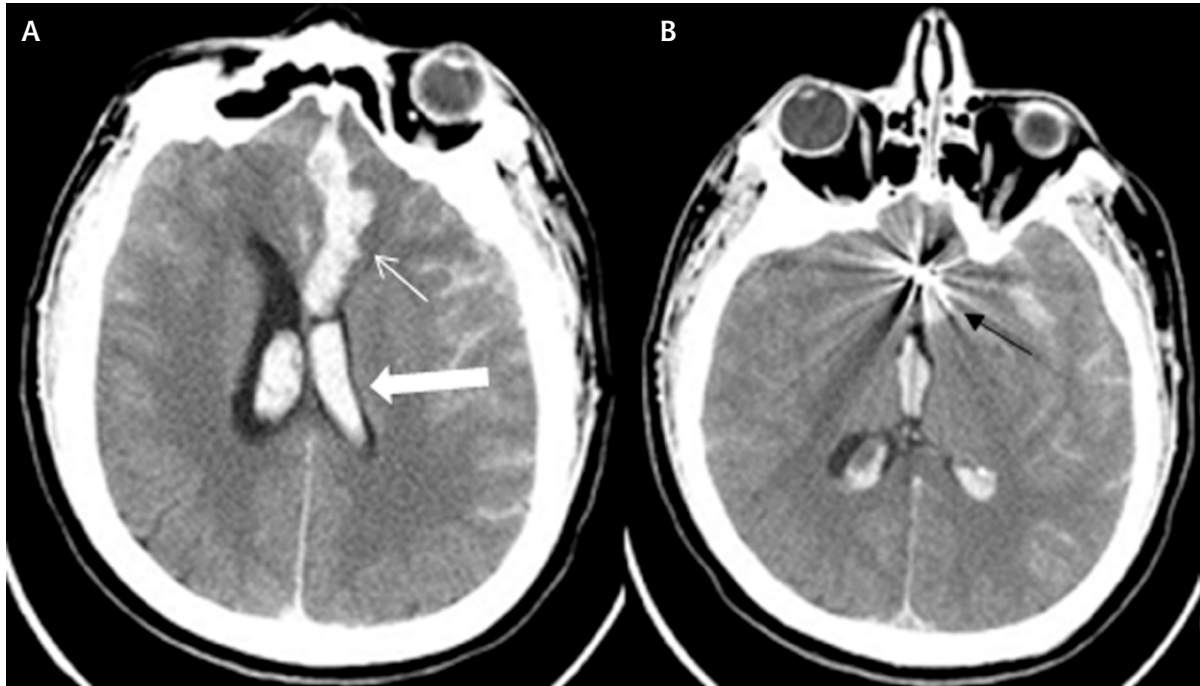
A computed tomography (CT) scan of the patient with subarachnoid hemorrhage on admission demonstrating: (A) intracerebral hemorrhage (white thin arrow) with intraventricular extension (white thick arrow); (B) coiled aneurysm of anterior communicating artery and the blood in fourth ventricle (black arrow)
